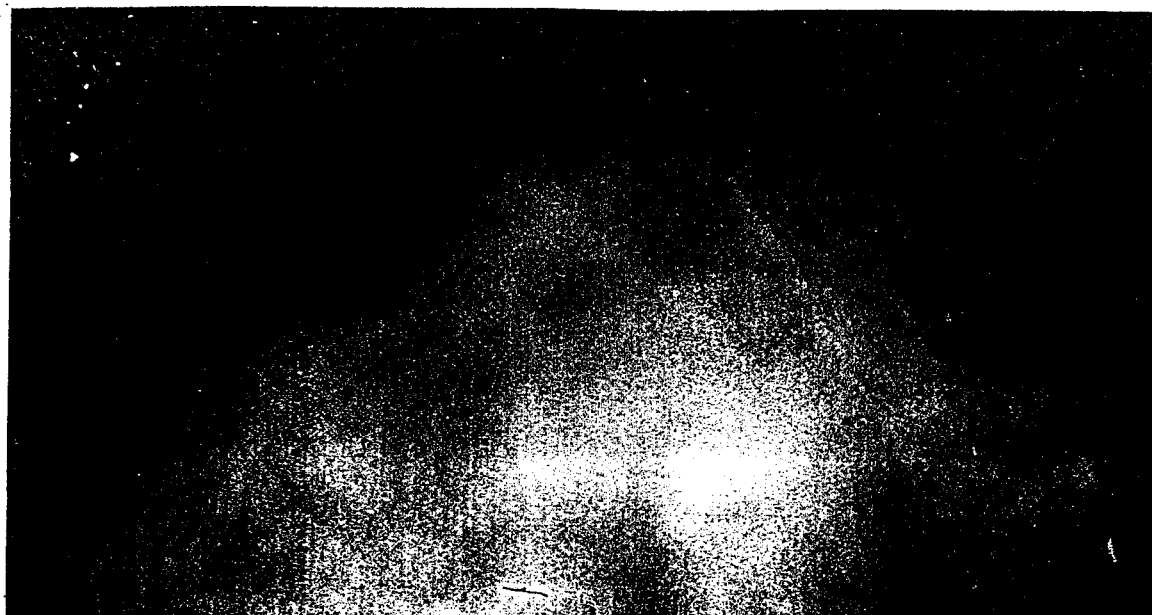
(a) Left breast, x-ray image.
